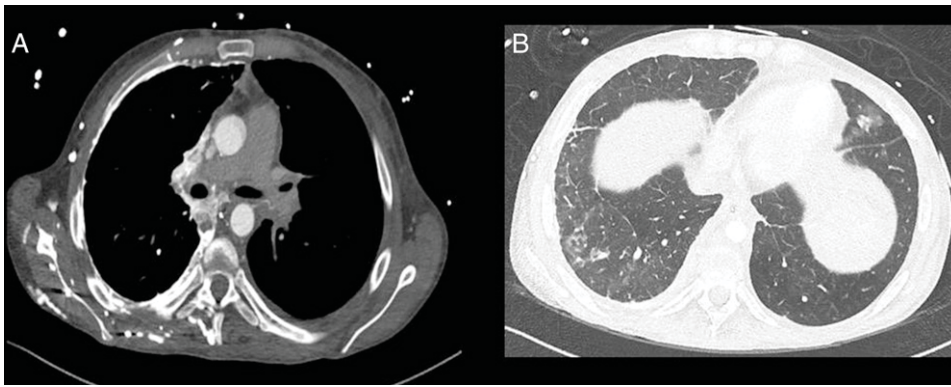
CT scan with iodine contrast administered through the right antecubital vein. A, Extensive chest wall collaterals are visible. There is almost no contrast in the right atrium and the pulmonary arteries, but dense contrast enhancement in the right pulmonary veins, left atrium, and left ventricle. B, Lung window.
